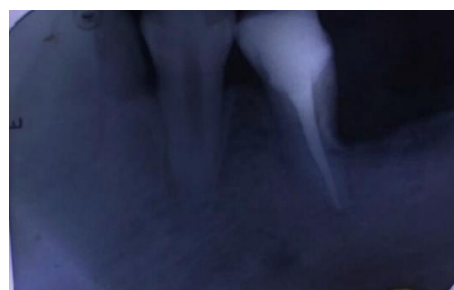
Follow up radiograph
